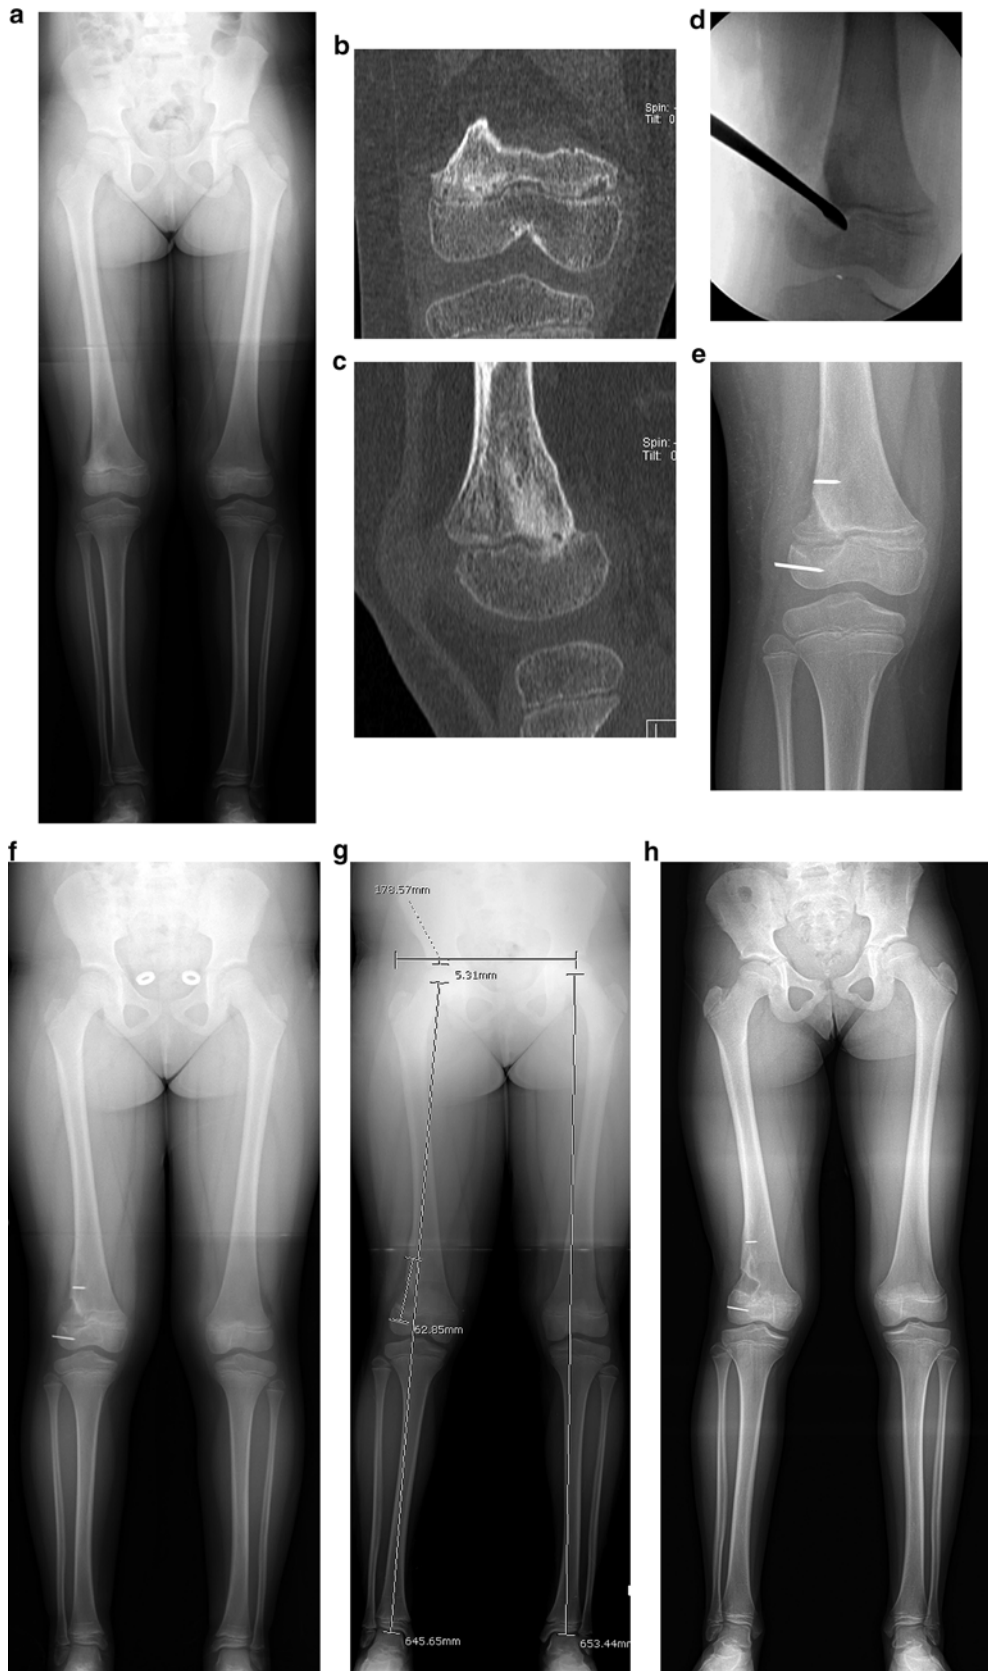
Case example of a 9-year-old female with a posttraumatic physal bar formation in the right distal femur. (a) Standing AP demonstrating right distal femur physal bar. (b, c) Coronal and sagittal slice of a CT scan showing lateral distal femoral bar with less than 20 % of physis involvement. (d) Fluoroscopic image showing curettage of physal bar. (e) Postoperative AP after physal bar resection. K-wires are placed in order to follow eventual growth; radiolucent cranioplast is
